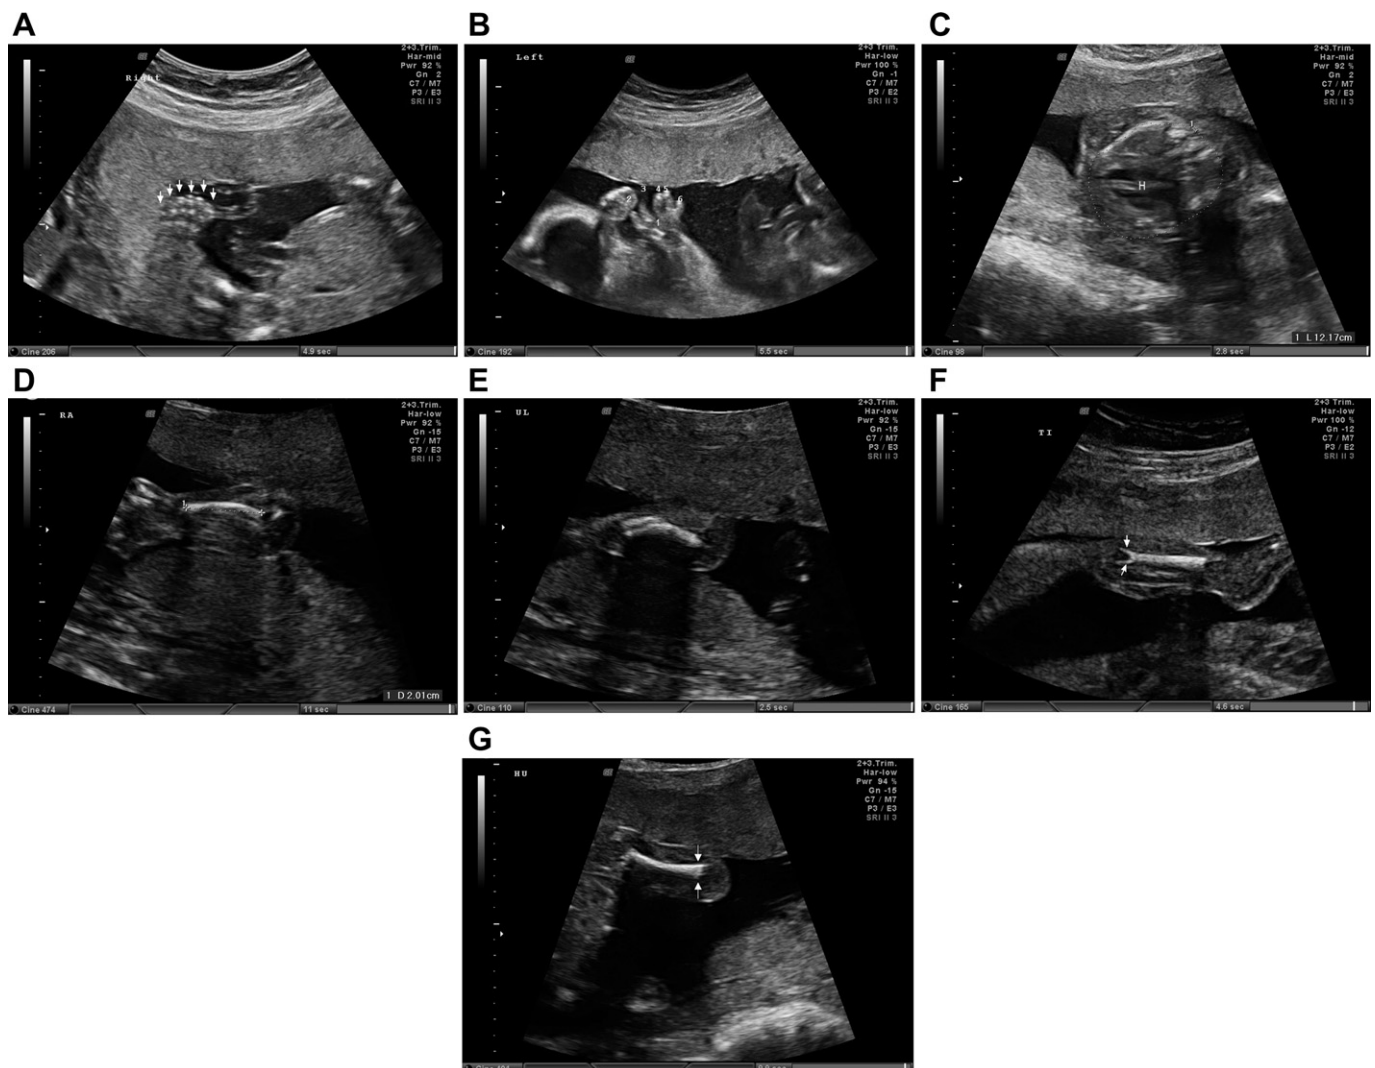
Prenatal ultrasound at 21 weeks of gestation shows (A) polydactyly of the foot; (B) polydactyly of the hand; (C) short ribs and a narrow chest; (D) curved radius; (E) curved ulna; (F) marginal spurs (arrows) in tibia; (G) widened humeral metaphyses (arrows). H = heart.
